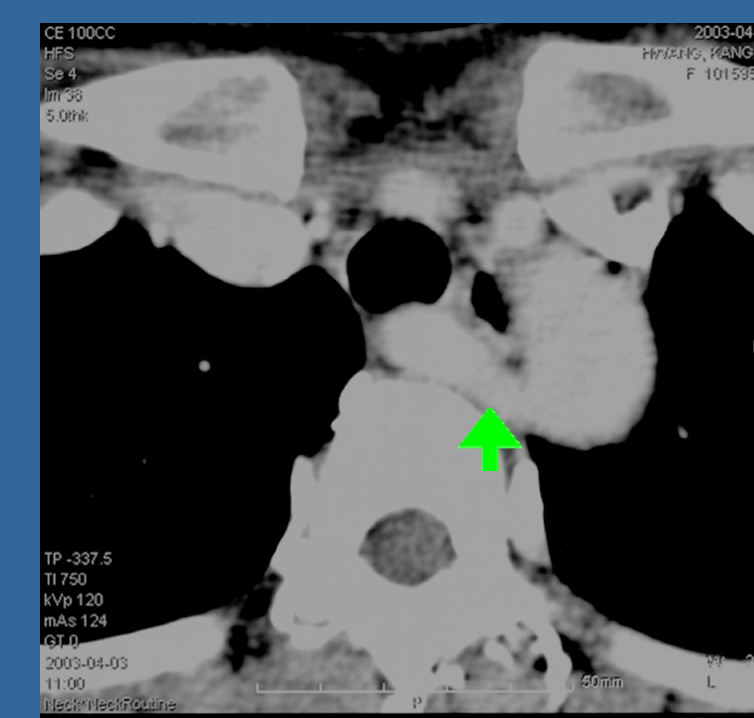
Arteria lusoria(arrow) on CT scan
